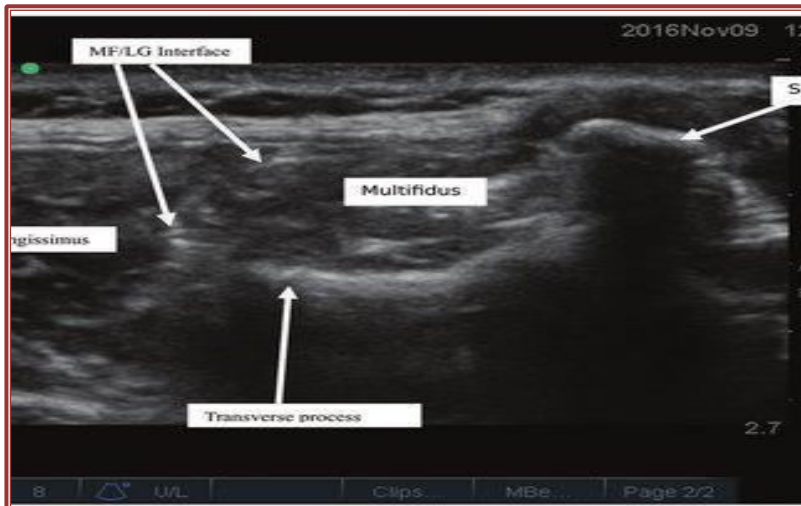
Ultrasound image of multifidus and longissimus thoracis interface
